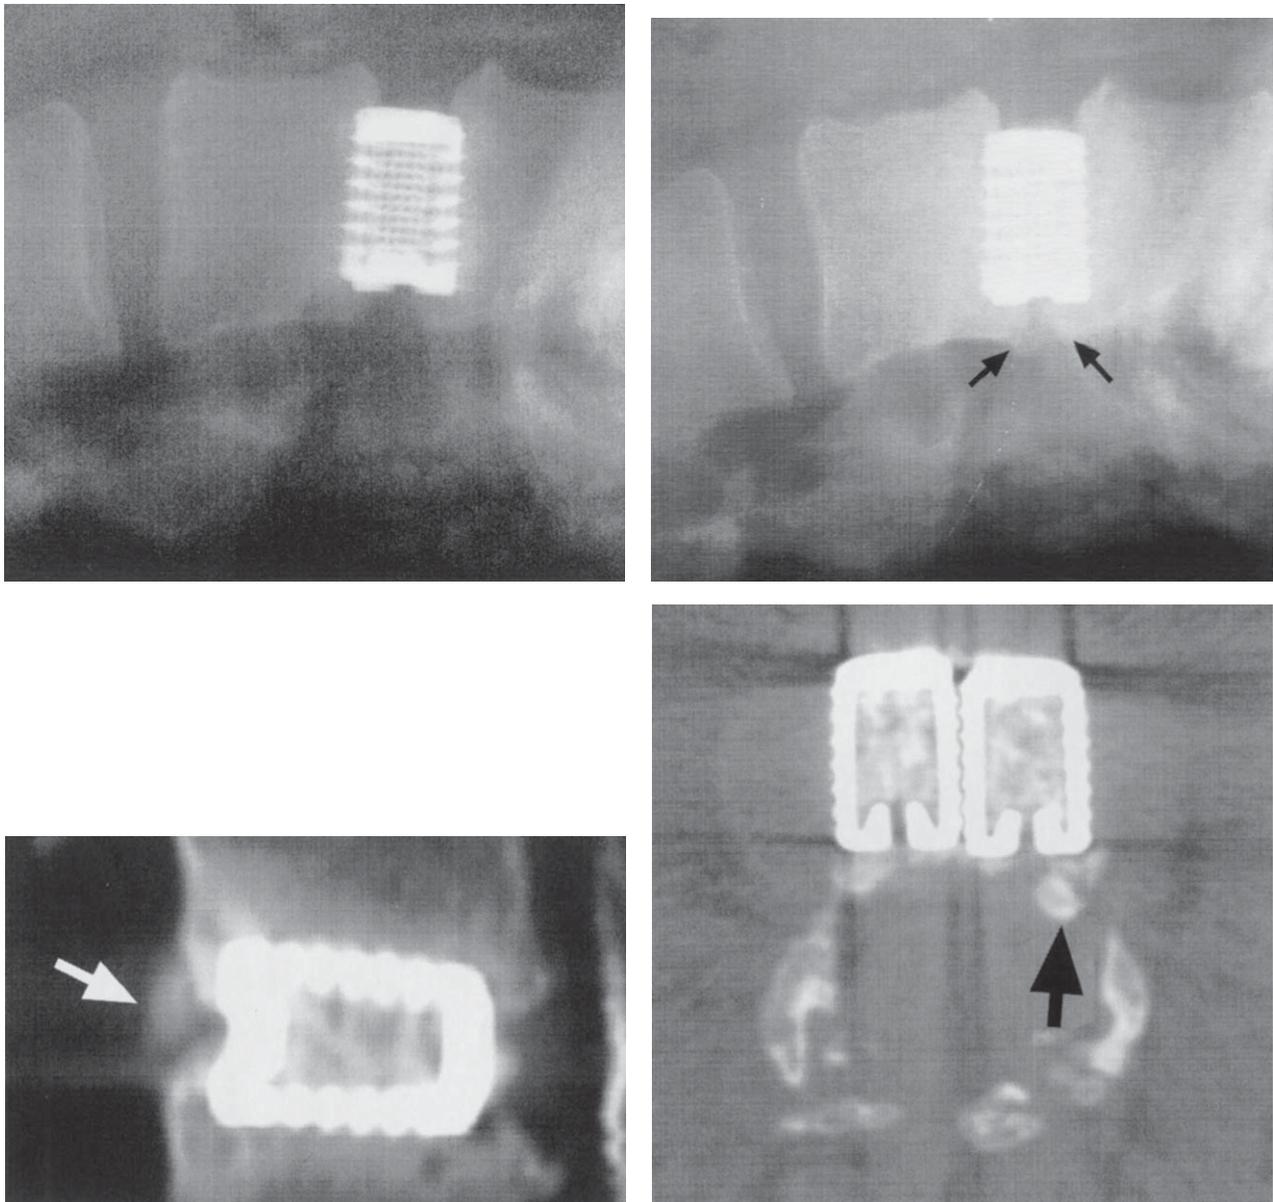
(Top left) Lateral radiograph of the L3–L4 interspace 3 months after a posterior lumbar interbody fusion (PLIF) procedure using autogenous iliac bone graft. The disc space height has been restored anatomically, and the cages are recessed by 3 mm within the disc space. There is no bone posterior to the cages. (Top right) Lateral radiograph at 24 months after the PLIF with autograft shows loss of disc space height, subsidence of the implants through the vertebral end plates and new bone formation posterior to the cages (arrows). The posterior bone formation extends into the spinal canal. (Bottom left) Sagittal computed tomography (CT) scan reconstruction across the L3–L4 interspace at 20 months after the PLIF using autograft confirms that there is new bone formation posterior to the implants that extend into the spinal canal (arrow). (Bottom right) Axial CT scan across the L3–L4 interspace at 24 months after surgery shows new bone formation (arrow) extending into the spinal canal.
